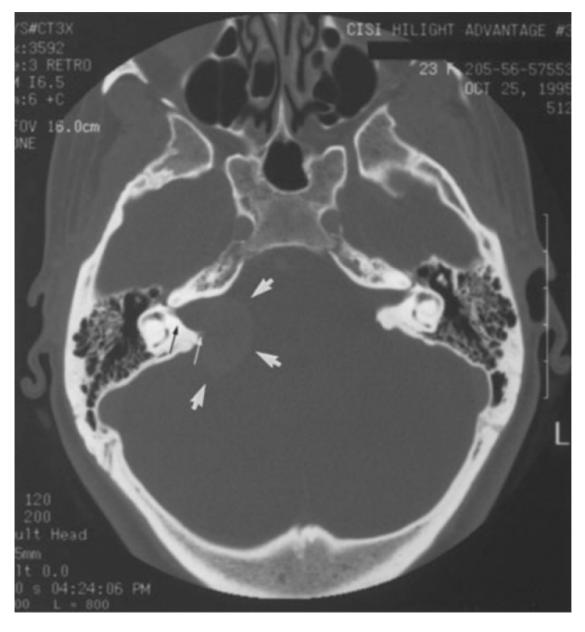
Bone algorithm computed tomography scan of a right acoustic neuroma. Note widening of the internal auditory canal. Approximately 7 mm of bone from the posterior lip of the porus acusticus can be drilled safely before the posterior semicircular canal is entered (*small arrows*). *Large arrows* outline the margin of the tumor.
